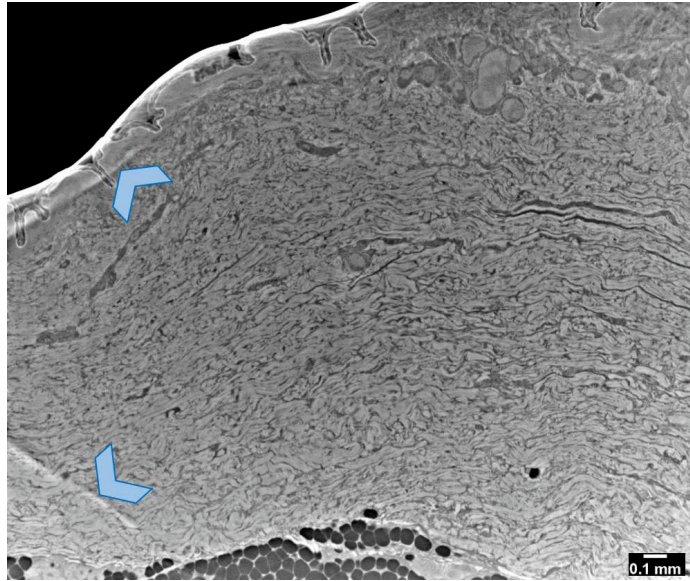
The formation of an air bubble is visible as a dark area above the external layer of the embedded tissue in agar. This is attributed to the X-ray exposure of the agar medium. Light blue arrows point at the artifacts induced by the high difference in refractive index. The experiment was conducted in parallel geometry, using the propagation-based setup available at the SYRMEP beamline (Elettra synchrotron of Trieste, Italy). Further experimental details: polychromatic beam, 21 keV average X-ray energy, 2.0 μm pixel size, 20 cm SDD.
